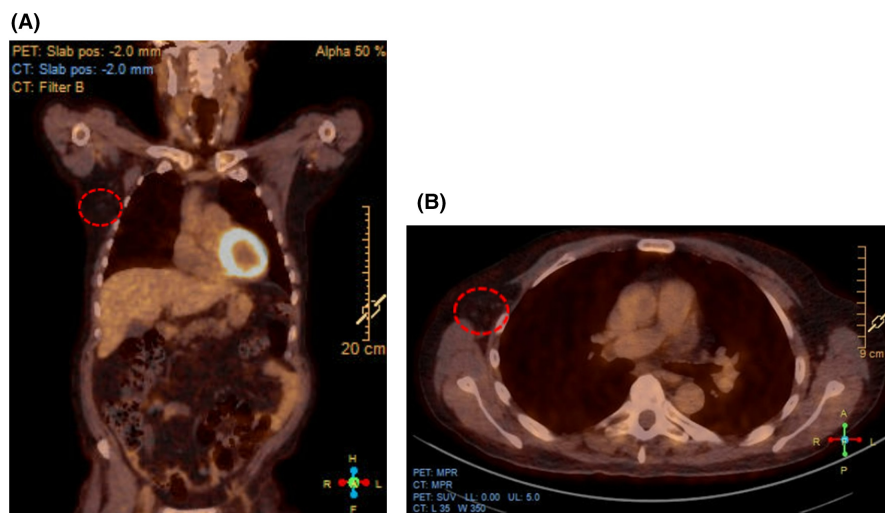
PET-CT performed after four cycles of belinostat therapy (1000 mg/m^2): (A) thoracic region, (B) axillar region. PET-CT, positron emission tomography computed tomography.
